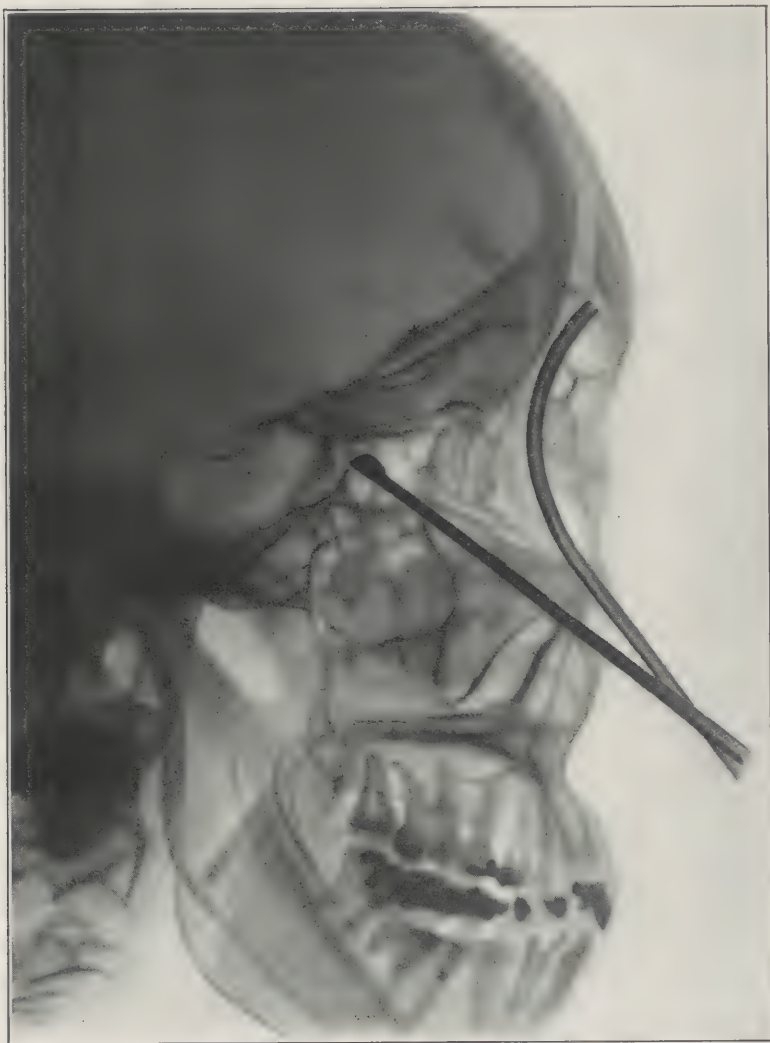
X-ray plate of the case of Mrs. D., shows the suction catheter in the frontal sinus and a curette in the posterior ethmoidal space.
